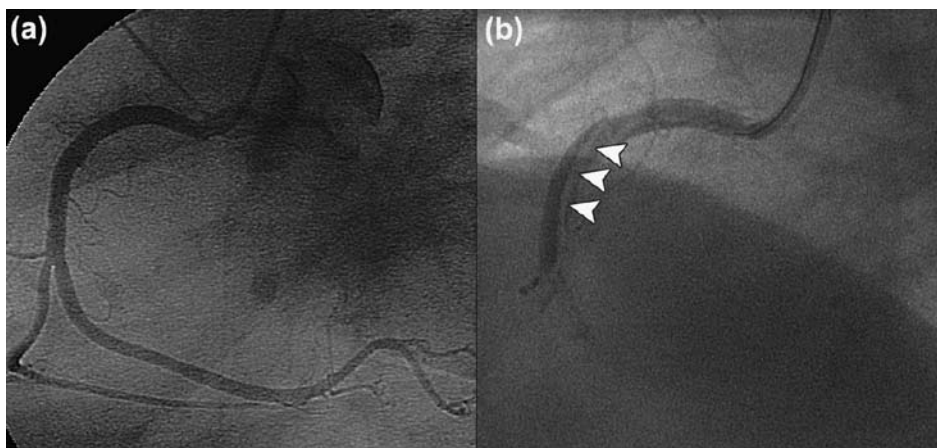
Invasive coronary angiogram of the right coronary artery. (a) Normal appearance of the vessel at initial catheterization. (b) In order to perform an intravascular ultrasound of the vessel, the artery was intubated again 2 weeks later, which resulted in a proximal dissection of the vessel. The dissection flap is clearly visible (arrowheads).
